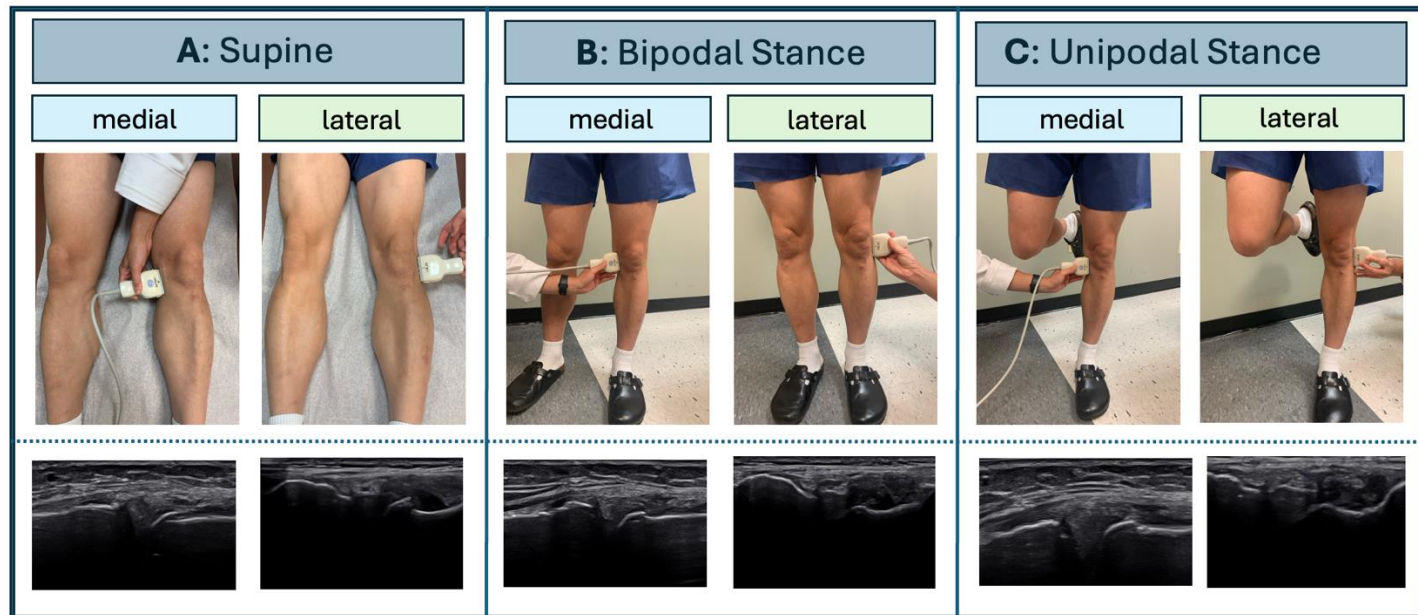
Acquisition of ultrasound measurements of all menisci in A) supine position (no weight-bearing), B) bipodal stance (half body weight), and C) unipodal stance (full body weight).
